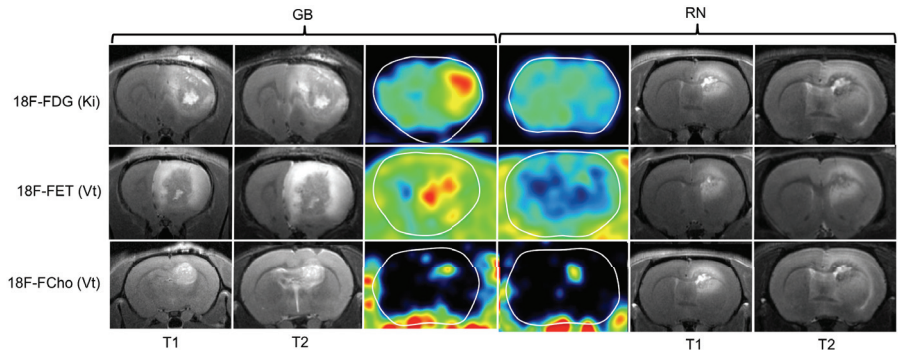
T1- and T2-weighted MRI and parametric maps of the Patlak slope (K_i) and Logan slope (V_t) in GB and RN. K_i of ^{18}F -FDG (row 1) and V_t of ^{18}F -FET (row 2) were higher in GB than in RN. V_t shows heterogeneously increased values both in GB and RN lesions on ^{18}F -FCho PET (row 3).
